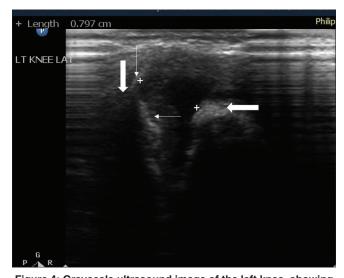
Greyscale ultrasound image of the left knee, showing splaying (thin vertical white arrow) and fraying (thin horizontal white arrow). There is a widening of growth seen. Cortical irregularity is also seen on both the epiphyseal (thick horizontal white arrow) and metaphyseal side (thick vertical white arrow)
